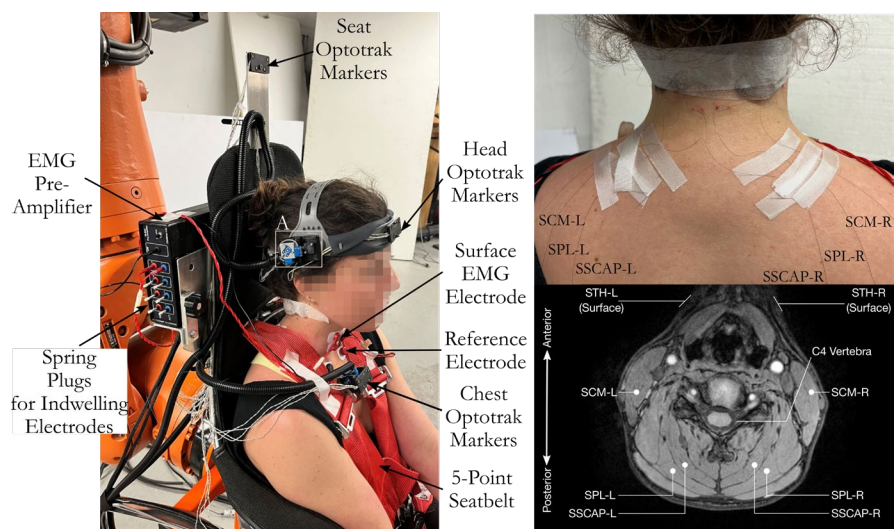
Left: experimental, electromyography and Optotrak marker setup. Top right: wire electrodes after insertion. Bottom right: exemplar transverse magnetic resonance image of a neck at C4 level with indwelling wire electrode insertion locations.
